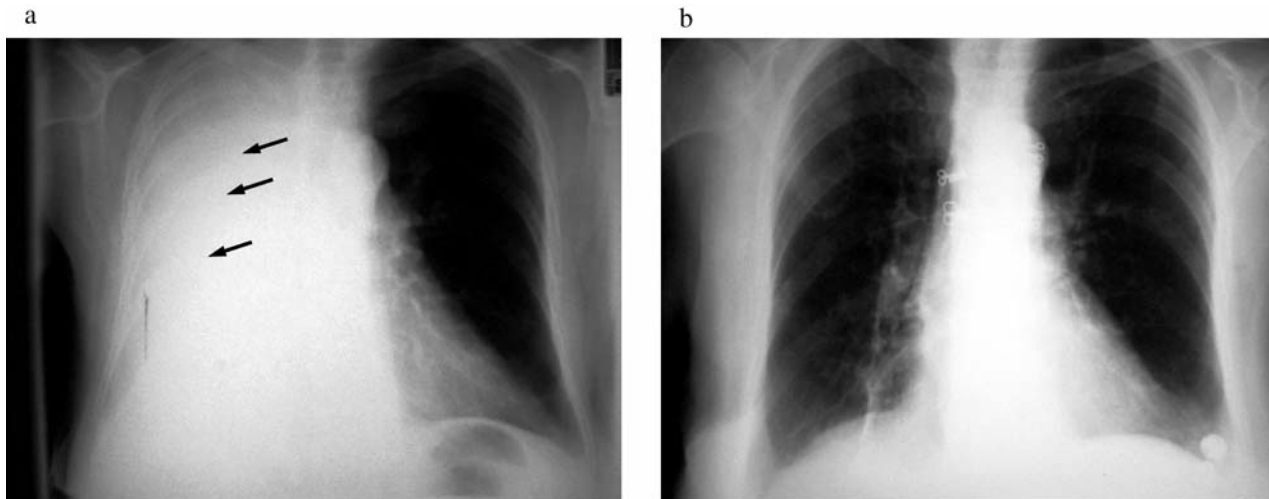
a*, Chest X-ray of patient 1 on admission. Pleural effusion occupying almost entirely the left pleural cavity can be seen. *b*, The same patient after pleurodesy. Complete resolution of the pleural fluid is clearly evident.
